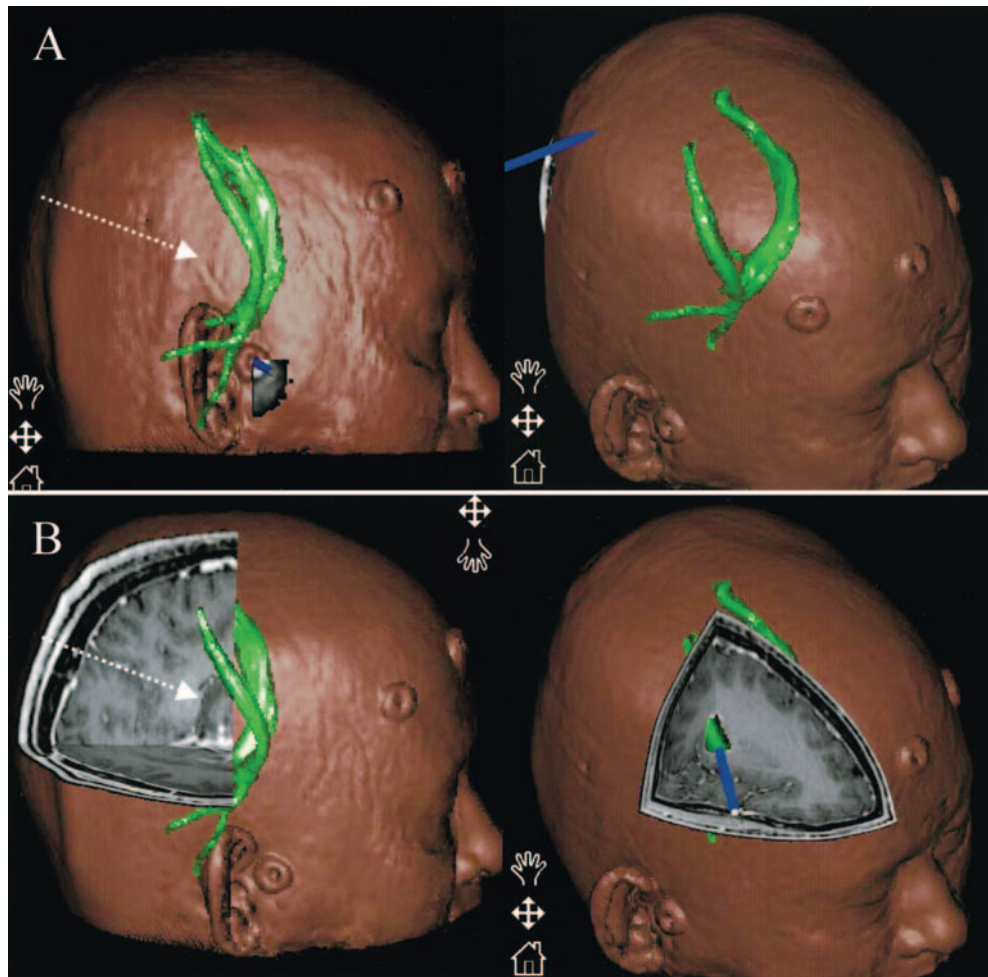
Case 1. Three-dimensionally reconstructed whole-head MR imaging data on the neuronavigation system, both the plain mode (A) and the cut mode (B), displaying the CST (green). *White arrows* indicate the surgical route for approaching the thalamic tumor.
